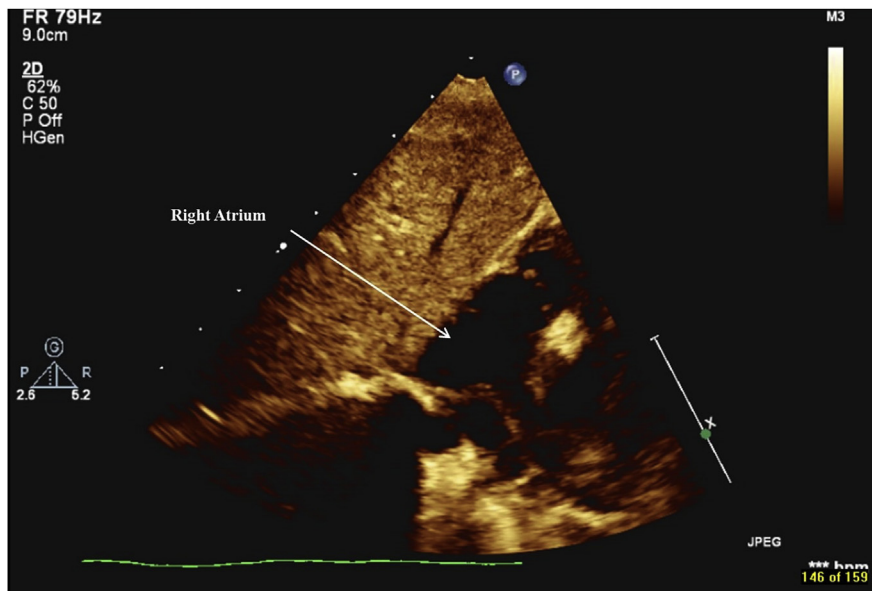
Echocardiography post-operative day 96.
